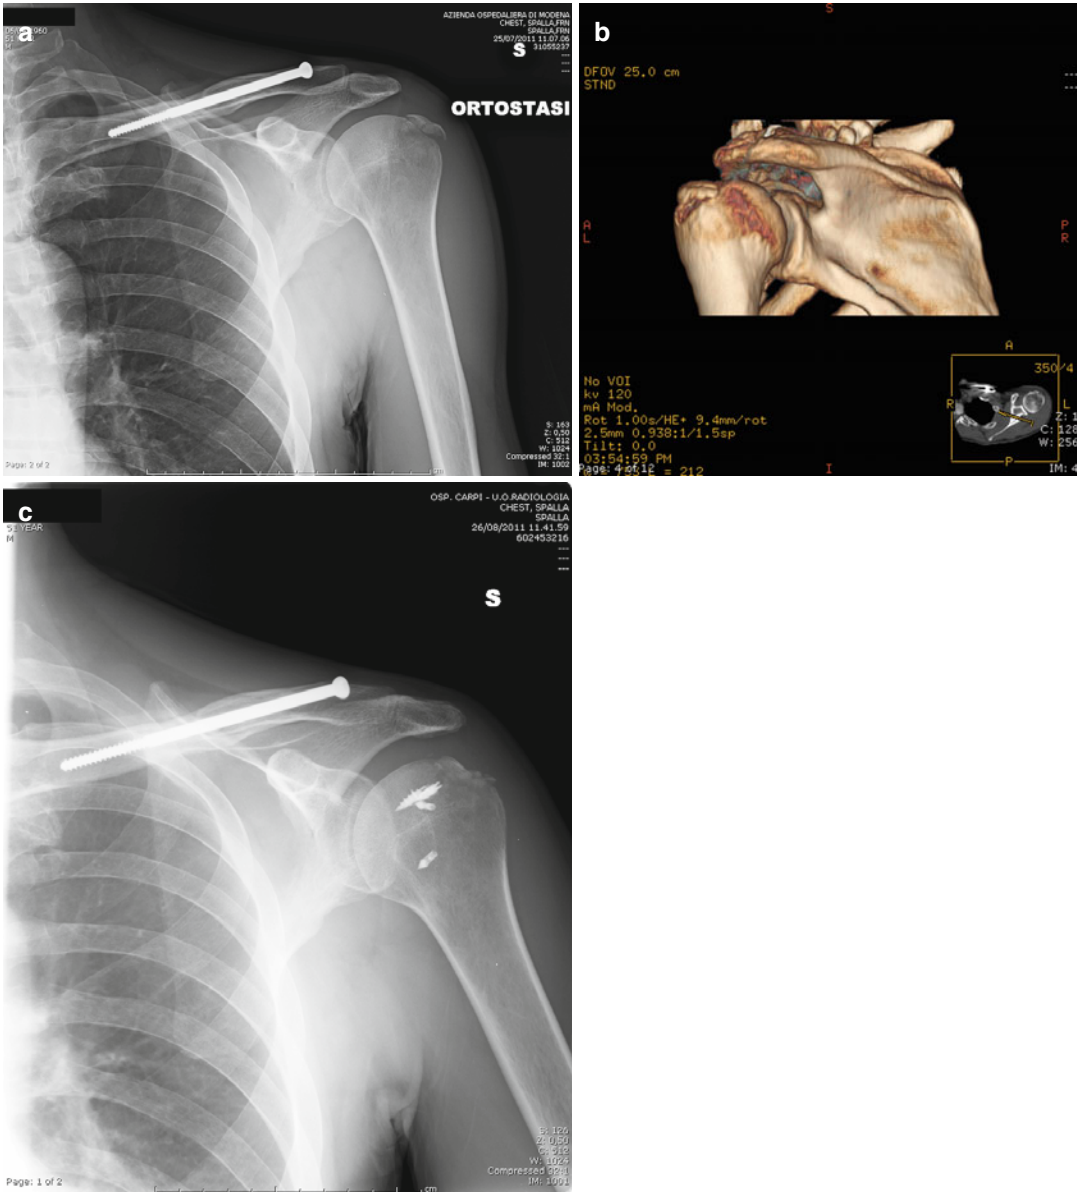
(a) Several small fragments of greater tuberosity fracture: X-ray. (b) 3D-CT fracture view. (c) Arthroscopic indirectly fixation with transosseous
